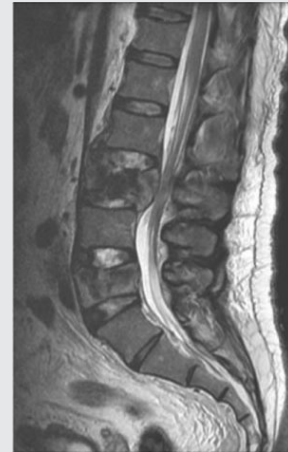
MRI scan sagittal view with intact posterior ligamentous complex.
